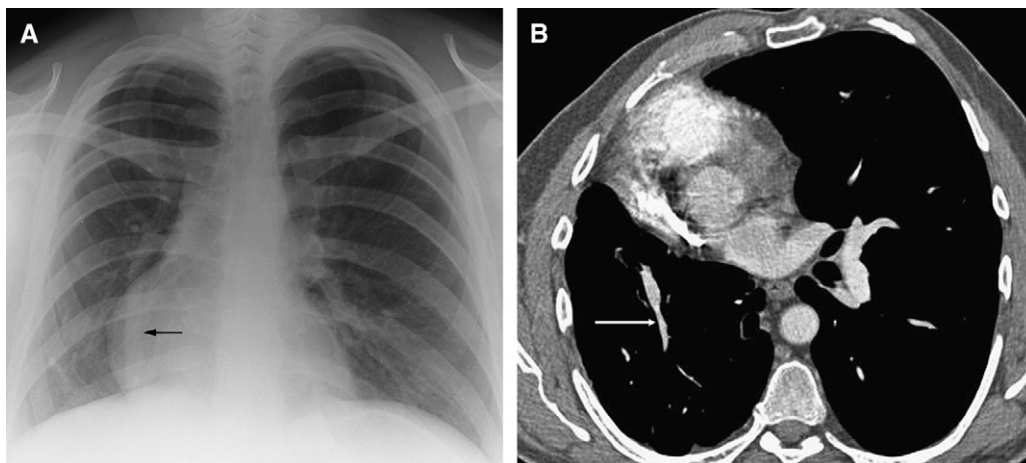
An asymptomatic 34-year-old woman. (A) Chest radiograph, showing loss of volume in the right hemithorax, rightward shift of the mediastinum, and a vessel is seen coursing inferiorly from the right hilum towards the diaphragm (arrow). (B) Transaxial contrast-enhanced CT image, showing a hypoplastic right lung and the anomalous vein coursing through it (arrow).
